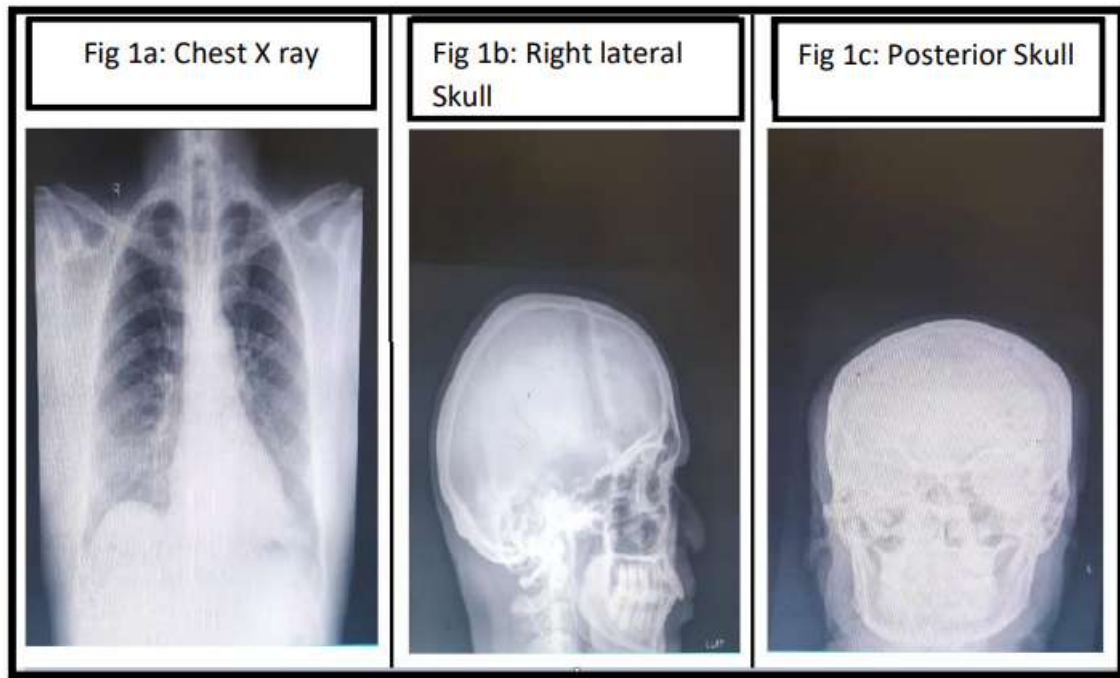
X-ray of chest and skull
